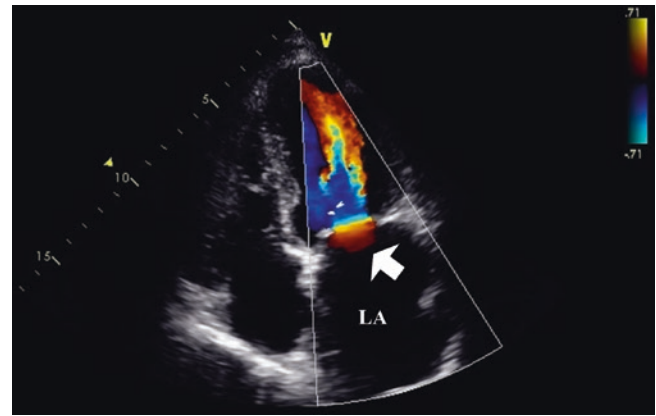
Mitral stenosis, color Doppler examination in the apical four-chamber view. Color Doppler examination in this view shows color flow convergence (*arrow*) in the left atrium (LA) which indicates blood flow acceleration toward the narrowed orifice of the mitral valve in diastole. See also Video 20.3
